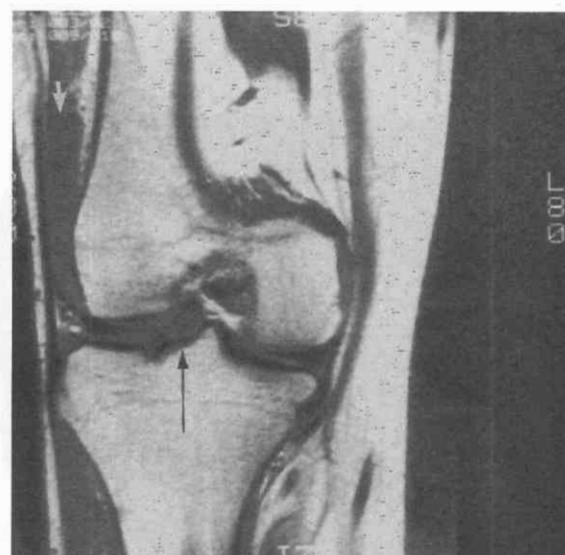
Anterior cruciate ligament (ACL), coronal view. Coronal T1-weighted image shows the fanlike ACL insertion (black arrow). Joint fluid is evident at the suprapatellar gutters (white arrow).
